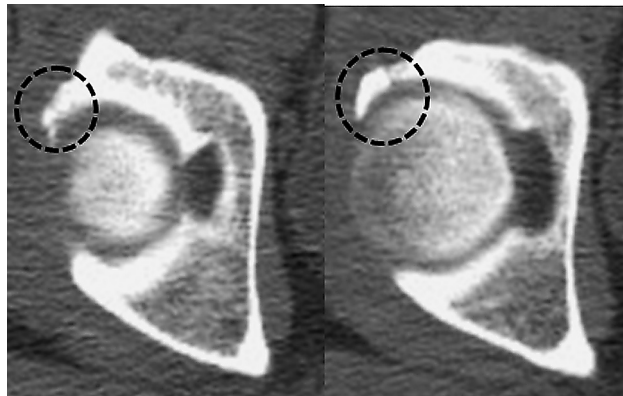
Axial CT showed abnormal bony coverage of acetabulum.
